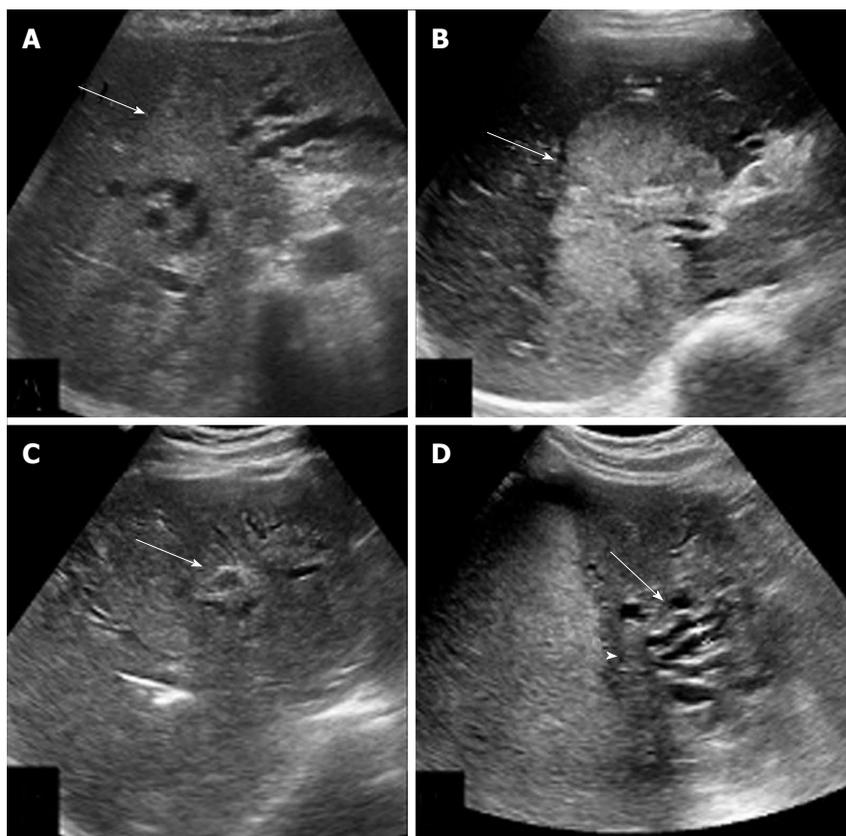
Ultrasonographic appearances of hilar cholangiocarcinoma. A: Isoechoic lesion (arrow) involving primary biliary confluence; B: Hyperechoic mass (arrow) involving hilum; C: Infiltrative lesion (arrow) with periductal wall thickening; D: Atrophy of left lobe with crowding of bile ducts (arrow) due to isoechoic hilar mass (arrow head).
